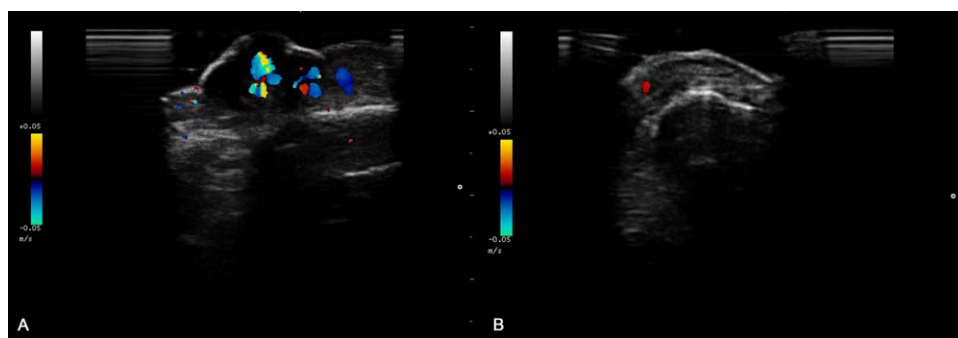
Color Doppler ultrasound imaging. (A) Before treatment. Increased blood flow within the lesion. (B) After treatment. No evidence of increased vascularization.
